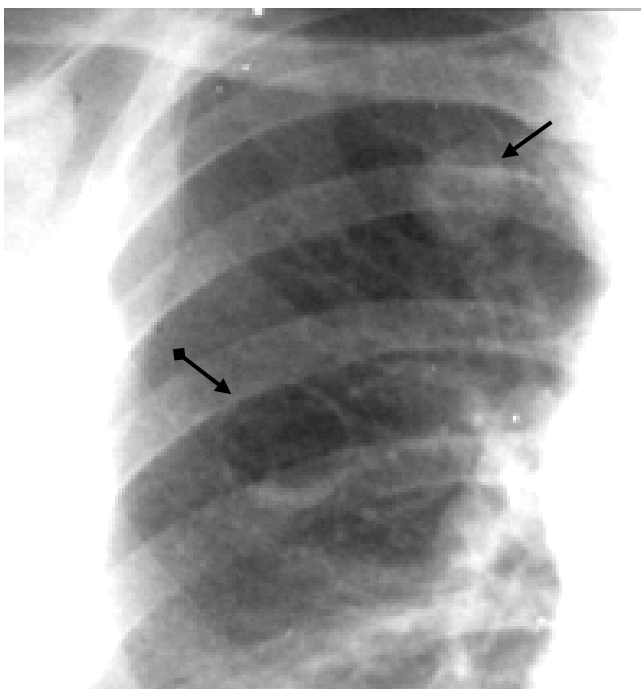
Enlargement radiograph of a thorax in direct projection. Under clavicle to a zone of the right pulmonary field a round shadow with the accurate smooth contours, homogeneous, average intensity (arrow). In the right pulmonary field ring-shaped a shadow with accurate, thin, equal walls, at the bottom pole of this shadow a small congestion of a liquid with horizontal level (an arrow with a rhombus). Filled and emptied cysts the right lung
